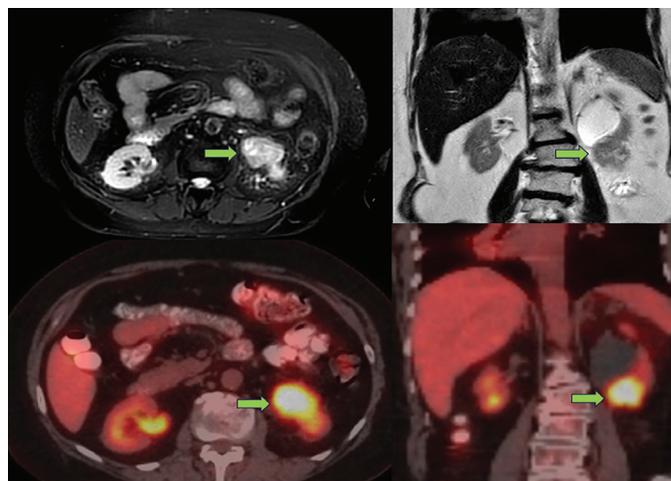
FDG PET/CT and MRI images of a kidney mass MRI (upper line) and FDG PET/CT (lower line) images of the kidney mass are shown. The green arrow indicates the kidney mass. MRI shows a lesion approximately 4 cm in size in the lower pole of the kidney. This lesion uptakes FDG ($SUV_{max}=13.6$)
